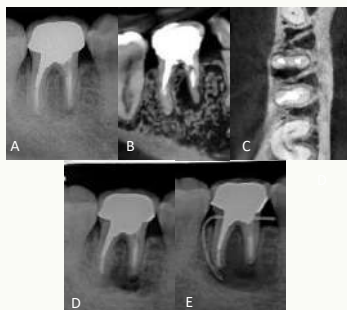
(A) Periapical radiograph. Radiolucency on furcal area of tooth #30. (B) Coronal plane, CBCT scan. (C) Axial plane of middle root, CBCT scan. (D) Post-operative radiograph. Periradicular surgery with apicoectomy and MTA retrograde filling. (E) 5-month follow up. Gingival abscess appeared again and periradicular radiolucency enlarged.
